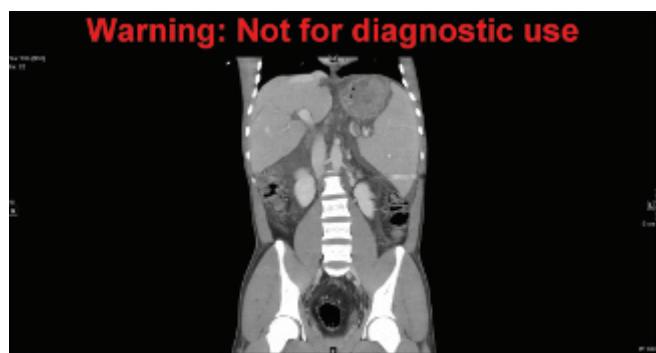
Noncontrast coronal computed tomographic scan of the abdomen.
